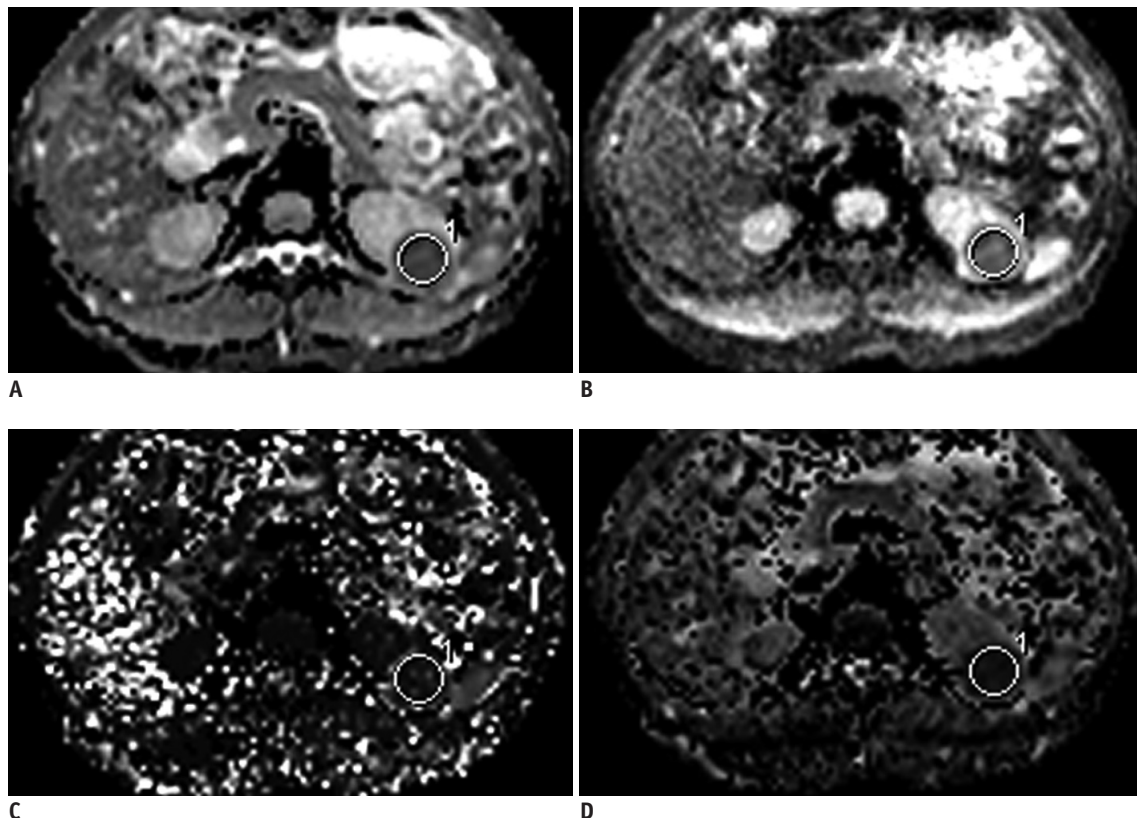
MR images in 52-year-old man with 3.5 cm surgically proven chrRCC in left kidney.
